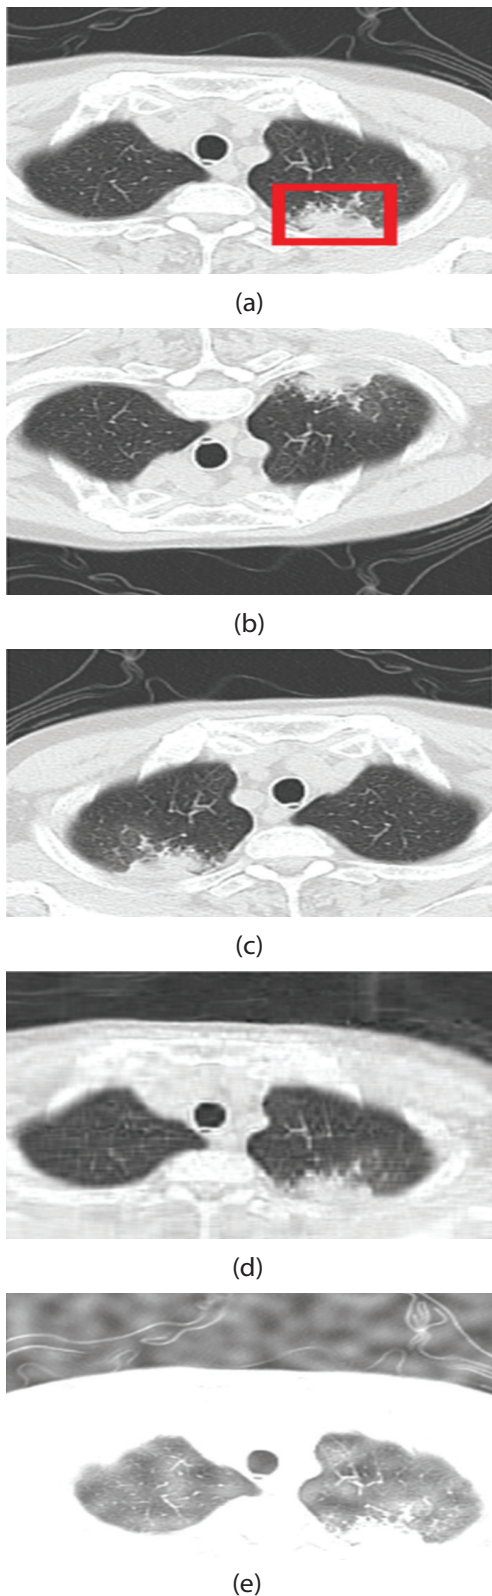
(a) Original CT scan (b) Vertical flipping (c) Horizontal flipping (d) PCA with 20 principal components (e) image overlay
